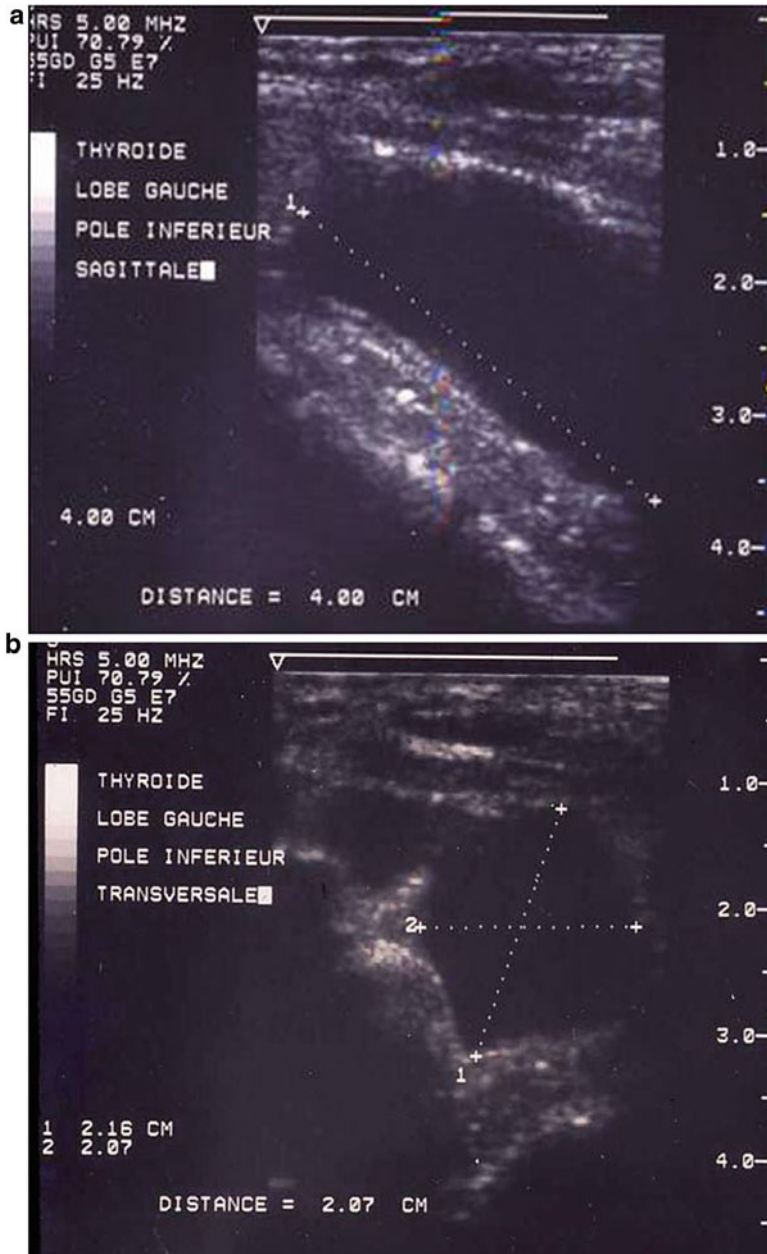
Sagittal (a) and transverse (b) ultrasound images of a left inferior nonfunctional parathyroid cyst. Ultrasound reveals a thin-walled, cystic, unilocular structure
